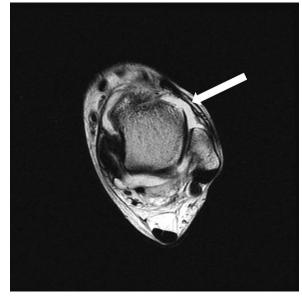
Magnetic resonance imaging (MRI) shows total rupture of the anterior talofibular ligament (arrow) on T2-weighted axial images. MRI = magnetic resonance imaging.
